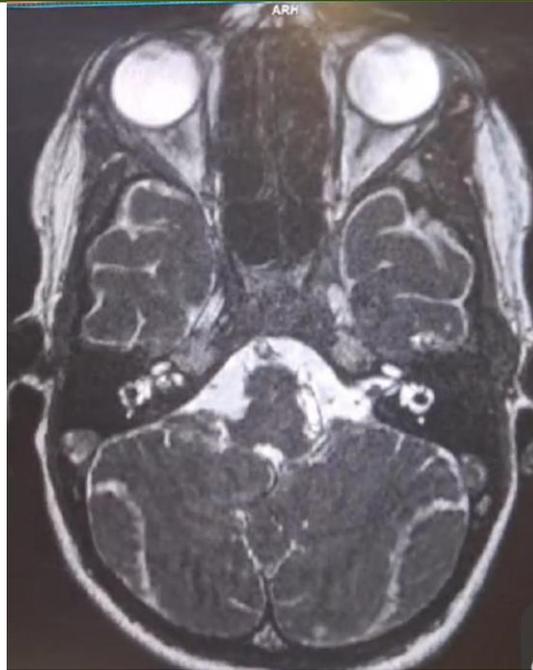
Normal MRI of the internal auditory canal and pontocerebellous angle and cerebral
